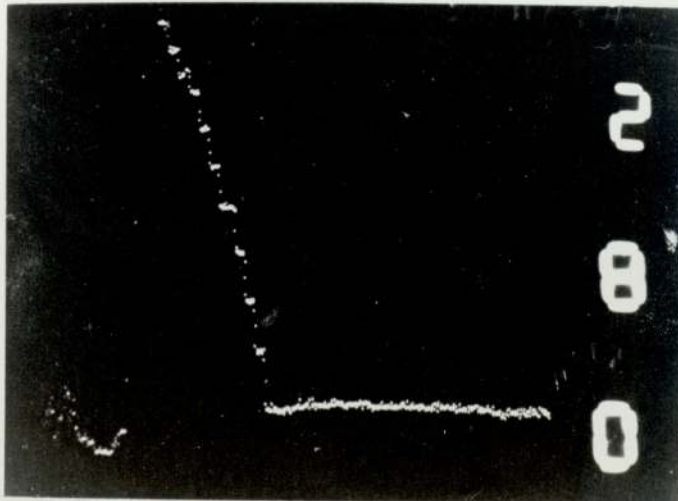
A trace taken with the X-ray tube in a tilted position
